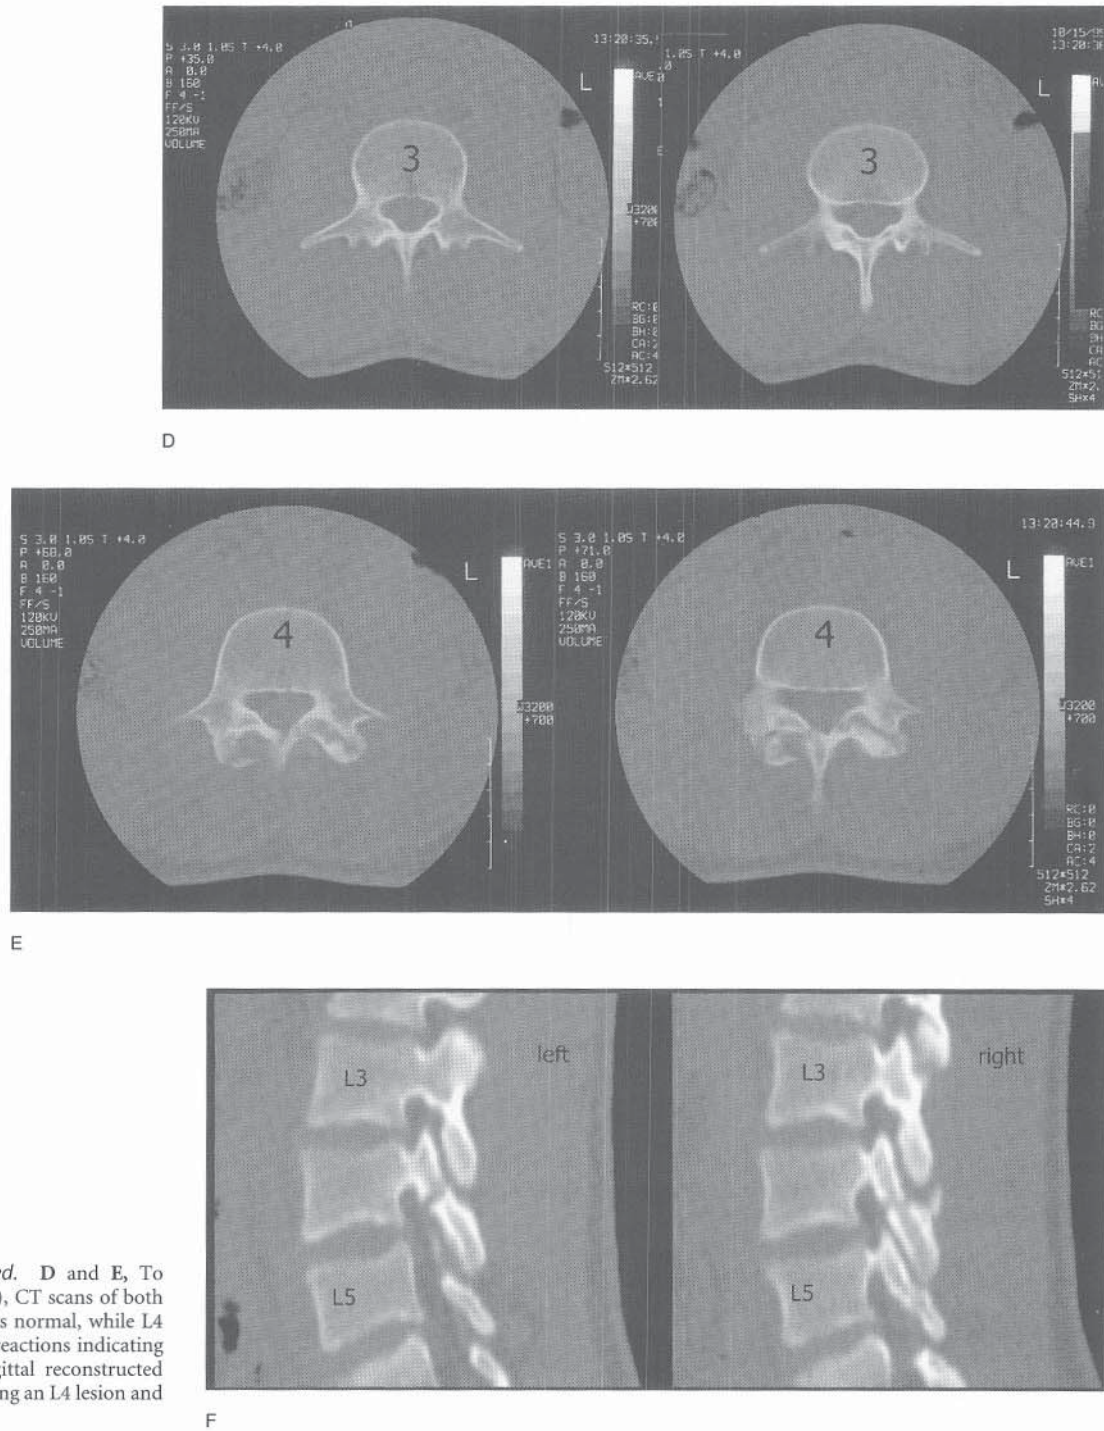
Continued.* D and E, To confirm the pars defect(s), CT scans of both levels were obtained. L3 is normal, while L4 clearly has bilateral pars reactions indicating stress fractures. F, A sagittal reconstructed image clearly demonstrating an L4 lesion and normal L3 pars.
